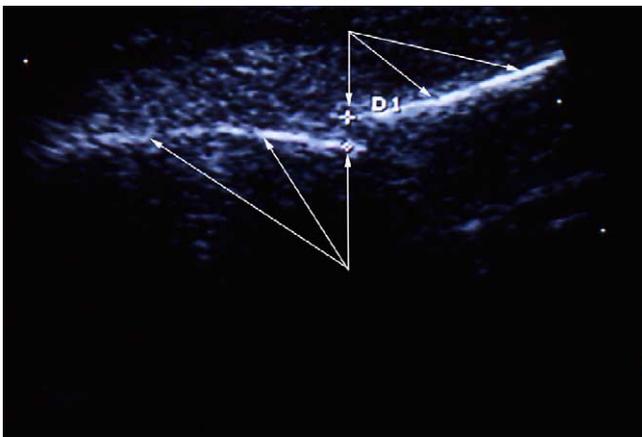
Ultrasound image of a medial orbital wall fracture. The dislocated fracture is marked with a cross. The upper and lower arrows show the unfractured area of the medial orbital wall.
